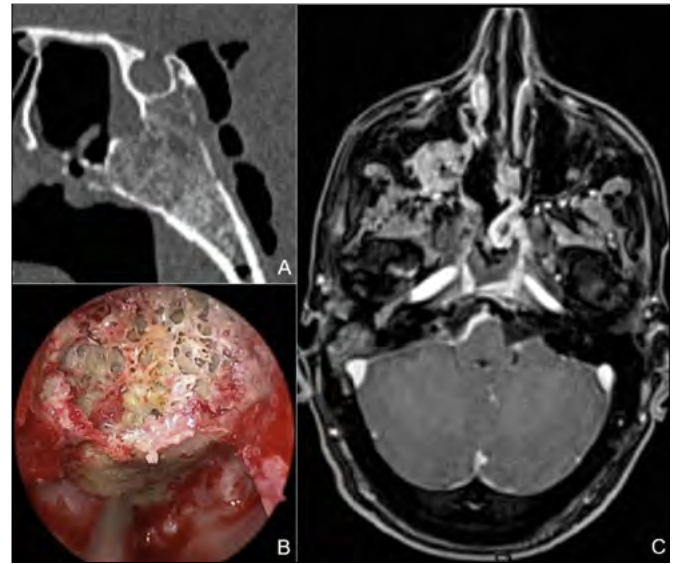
Images of a 36 years-old man who developed general disorientation, progressive tendency to drowsiness, cephalgia, fever and aqueous rhinorrhea²⁶. Four years before he was treated for undifferentiated NPC with a left-side modified radical neck dissection and elective chemo-radiotherapy, then a second line stereotactic radiotherapy (Cyberknife) for local relapse. At the time of admission CT scan revealed the presence of massive tension pneumocephalus with an erosion of infero-posterior parts of sphenoidal sinus and possible radionecrosis of the clivus (A). Nasal endoscopy revealed the presence of necrotic bone in the paramedian portion of the nasopharynx and active CSF rhinorrhea. The patient underwent endoscopic endonasal debridement of necrotic bone (B) and repair of the clival fistula with a pedunculated nasoseptal (Hadad) flap. Control CT and MRI cerebral scans showed progressive resorption of the pneumocephalus with the nasoseptal flap covering the bony defect (C).
